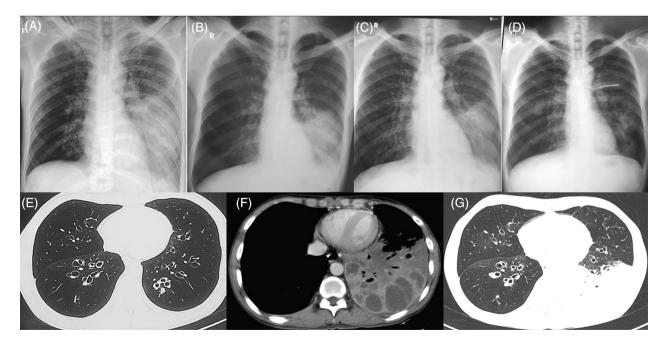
Chest x-ray (CXR) and CT scan of the male patient in case 2. (A) Initial CXR with opacity in the lower-half left lung. (B, C) Subsequent CXRs, taken every 14 days, demonstrated gradual improvement in the lower-half left lung. (D) CXR taken 1 month after the previous one revealed a nearly resolved lesion. (E) Baseline chest CT image displaying bilateral cylindrical bronchiectasis. (F) CT image during infection, displaying low-attenuation areas within the consolidated left lower lobe. (G) CT image during infection, showing bilateral bronchiectasis with an opacity in the left lower lobe.
